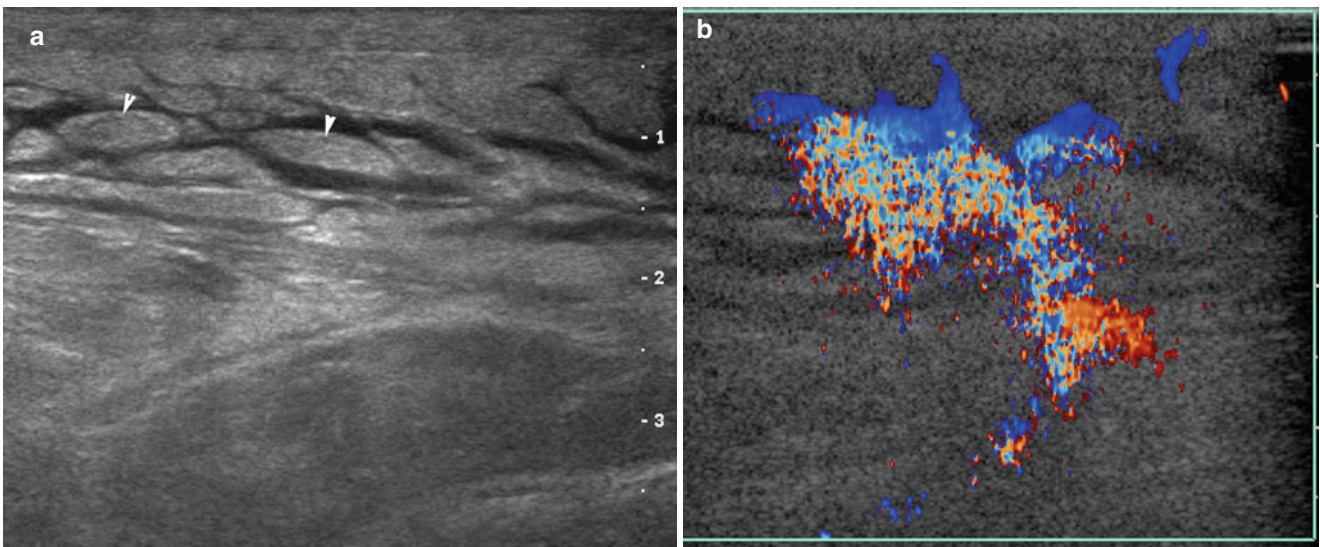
A 40 y/o male patient complaint of painful swelling over left calf. (a) Grey scale ultrasonography showing variable size homogeneous hyperechoic nodules (*arrowheads*) distributed in subcutaneous
